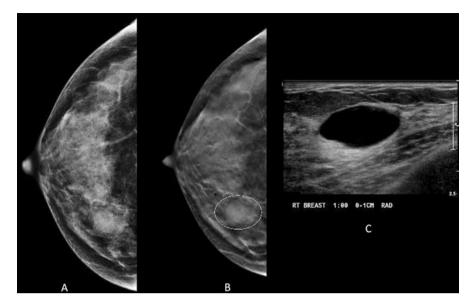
Forty-three-year-old woman with obscured mass in the inner right breast on conventional MLO view (a) Tomosynthesis reveals circumscribed margins (b) Instead of additional diagnostic mammographic views to better characterize the margins, the patient was recalled to undergo ultrasound that revealed a simple cyst (c)
